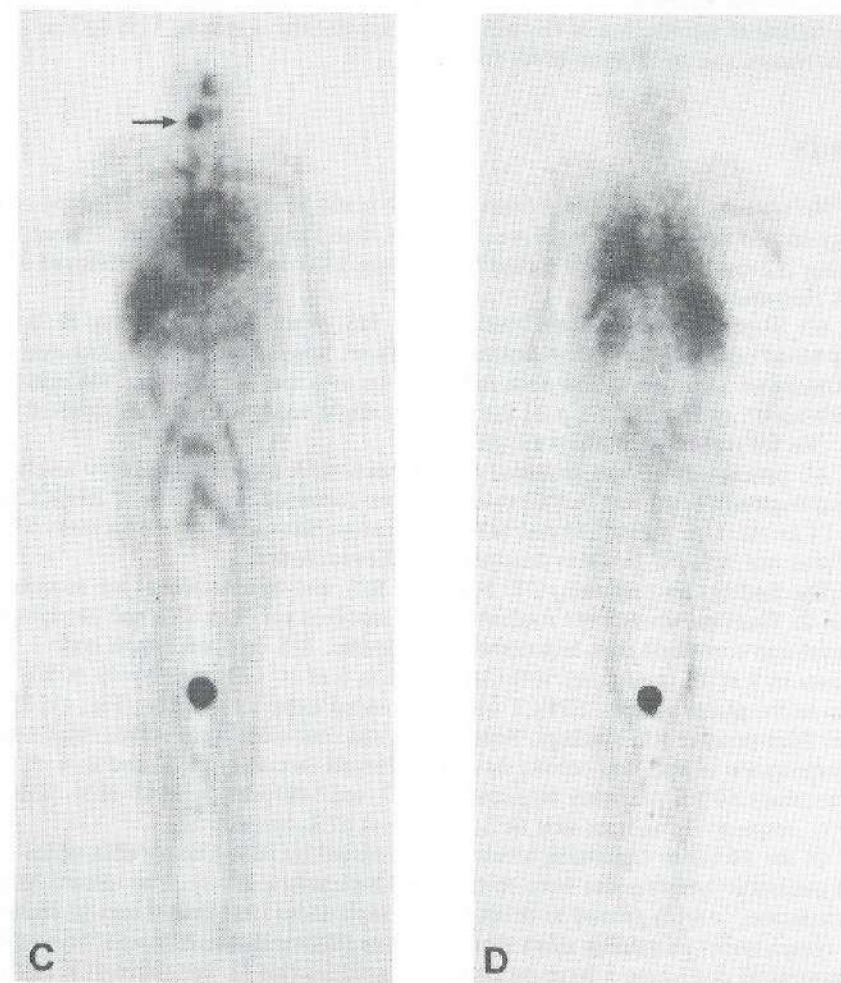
(A) Planar anterior image of the head and neck of patient 7 with a carcinoma of the right inferior alveolar process 16 h after injection of  $^{99m}\text{Tc}$ -labeled U36 IgG. Increased uptake is seen in the mouth on the right side. Only one spot can be distinguished (arrow). (B) A sagittal SPECT slice of the same patient shows the two separate spots, representing the primary tumor in the lower jaw (arrow) and the subdiaphragic lymph node metastasis (arrowhead). (C) Anterior and (D) posterior whole body images 16 h p.i.. Note the clear visualization of the primary tumor (arrow).
